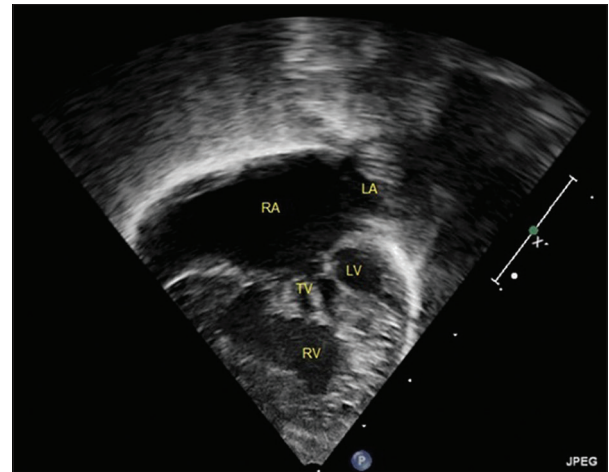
Transthoracic echocardiography (four chamber view) is showing mitral atresia, hypoplastic left ventricle, well developed right ventricle, intact interventricular septum and unrestricted interatrial communication (secundum atrial septal defect), signifying single ventricle physiology with hypoplastic left heart
